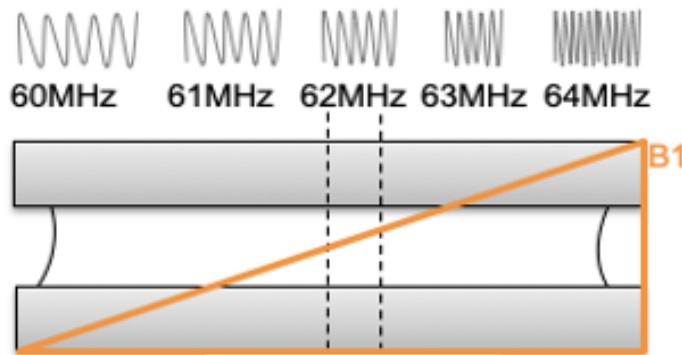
MRI layer selection
